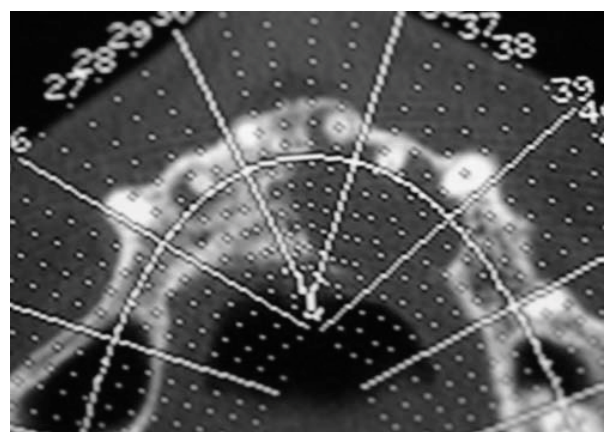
Axial view of the maxillary region. CT image.
